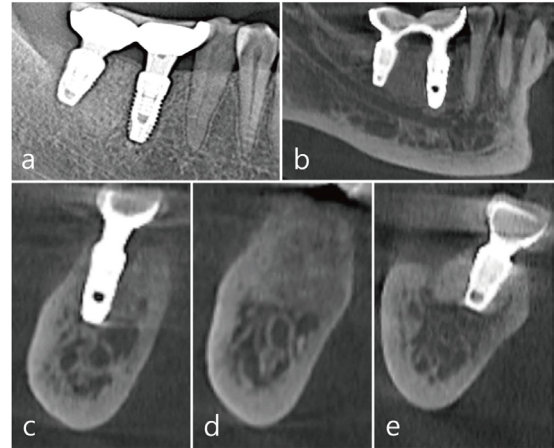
Radiological findings 1 year after prosthesis delivery. (a) On panoramic radiography, there was an increase in bone density around the previous lesion, and no recurrence was found; (b) In the panoramic image of CBCT, the bone density around the previous lesion and implant was significantly increased; (c-e) In the coronal image of CBCT, osteoporotic marrow showed increased radiopacity due to bone graft particles and bone formation.
